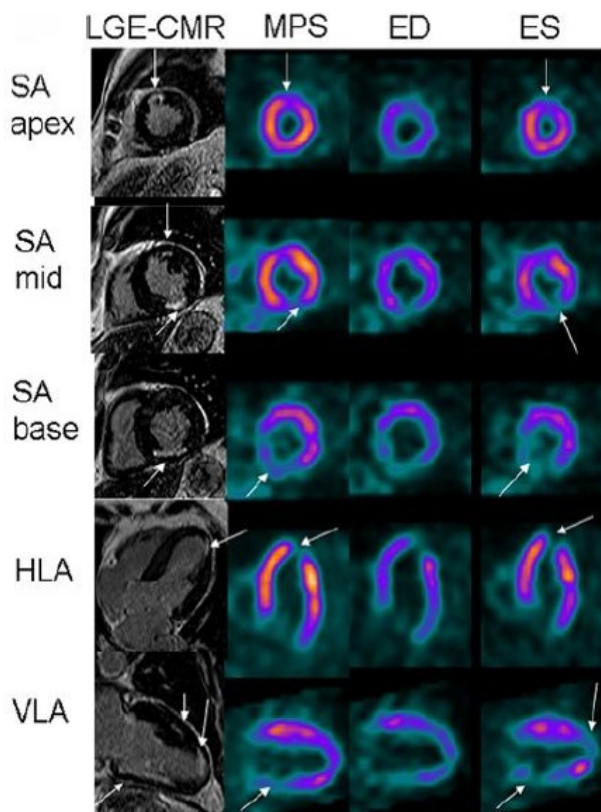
True positive myocardial perfusion SPECT (MPS). One apical/anterior and one inferior infarct, both of which are detected on MPS (arrows). HLA – horizontal long axis, VLA – vertical long axis.
